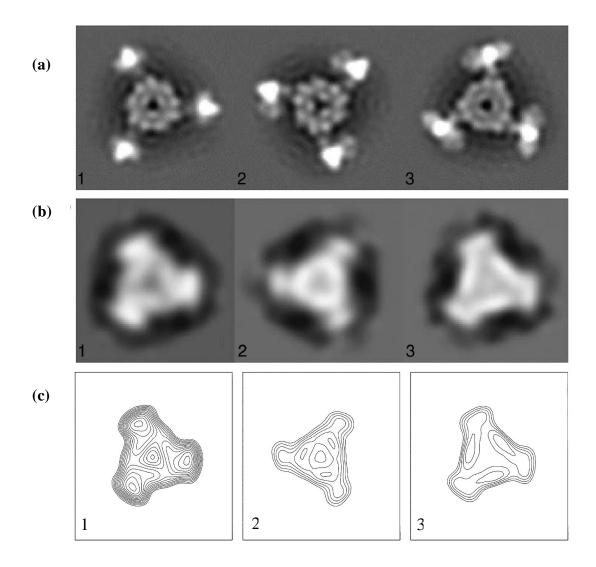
Different orientation of three individual myosin head. (a) cross-sectional view of myosin heads for the X-ray model, (b) The corresponding heads in the EM map, (c) Contour plot corresponding to cross sectional view (AL-Khayat et al., 2006).
